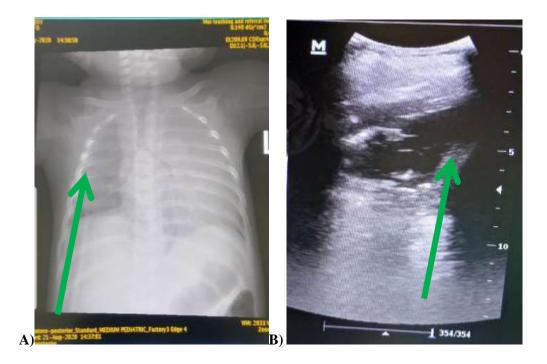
(A case of consolidation and pleural effusion). A 2-year-old male presented with clinical diagnosis of pneumonia. A; chest radiograph demonstrating left lung consolidation silhouetting the left cardiac border and pleural effusion blunting the left costophrenic angle. B; Lung ultrasonography demonstrates pleural effusion.
